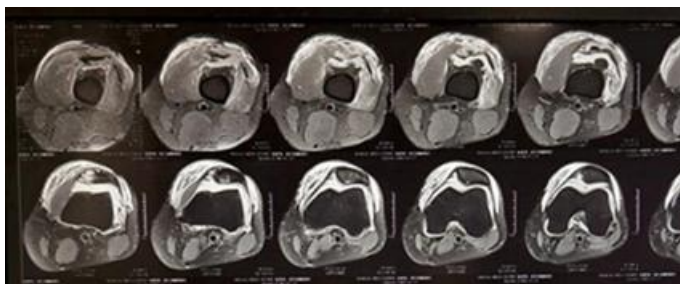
(c): Axial PD-FS MRI showing the level of tendon disruption and surrounding oedema
